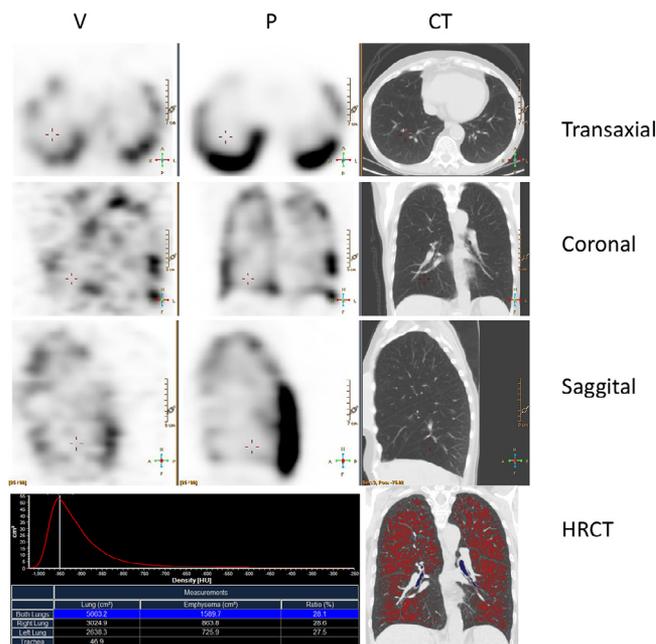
V/Q SPECT/CT showing the stripe-sign in a patient with severe COPD with emphysema. Both ventilation and perfusion is primarily localized in the periphery (stripe-sign) with severe reduction in central parts of the lobes corresponding to centrilobular emphysema on HRCT (28% emphysema). Upper row—transaxial. Second row—coronal. Third row—saggital. Lower row: density map histogram and image of HRCT with emphysema marked red. Left: ventilation ($^{81\text{m}}\text{Kr}$); mid: perfusion; right: low-dose CT. COPD, chronic obstructive pulmonary disease; HRCT, High-resolution CT; V/Q, ventilation-perfusion.
